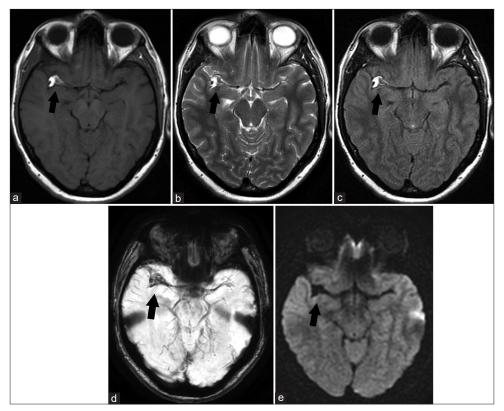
Non-contrast head MRI. Black arrow indicates right Sylvian fissure lipoma encasing right MCA. Axial scans show different signal intensity of the lesion in selected MRI sequences. (a) T1W CSE hyperintense lesion. (b) T2W FSE hyperintense lesion. (c) FLAIR hyperintense lesion. (d) SWI hypointense lesion with blooming artifacts. (e) DWI hypointense lesion. MRI: Magnetic resonance imaging, MCA: Middle cerebral artery, T1W CSE: T1W conventional spin echo, T2W FSE: T2W fast echo spin, SWI: Susceptibility weighted imaging, DWI Diffusion weighed imaging. FLAIR: Fluid-attenuated inversion recovery.
